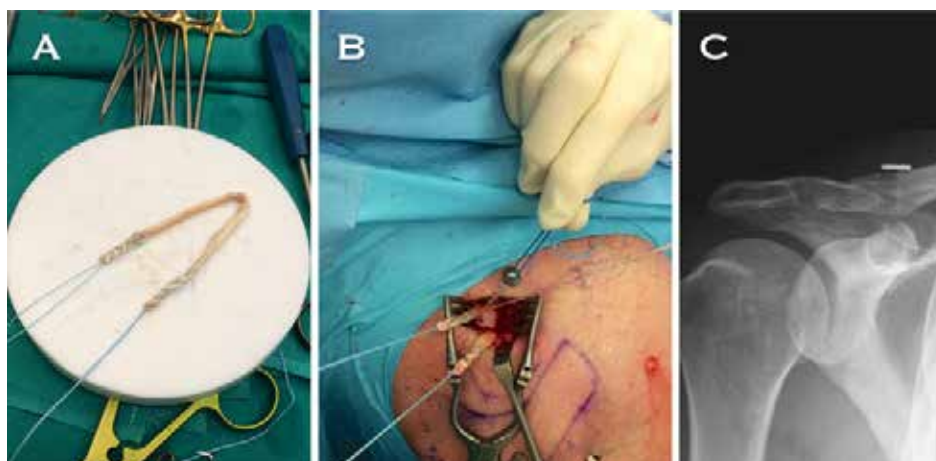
a Semitendinosus allograft after being sutured with a metal-core suture in both of its limbs. b Both limbs of the graft coming out of the clavicle once fixed in both tunnels with bio-tenodesis interference screws. The ZipTight is tied by threading the sliding suture in the washer. c AP X-ray of a right shoulder in which an
